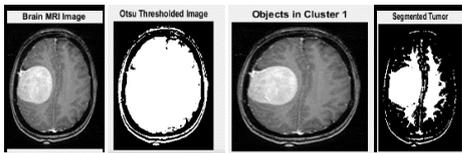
The MRI images with the DWT+PCA+KSVM with 5-cross validation.
